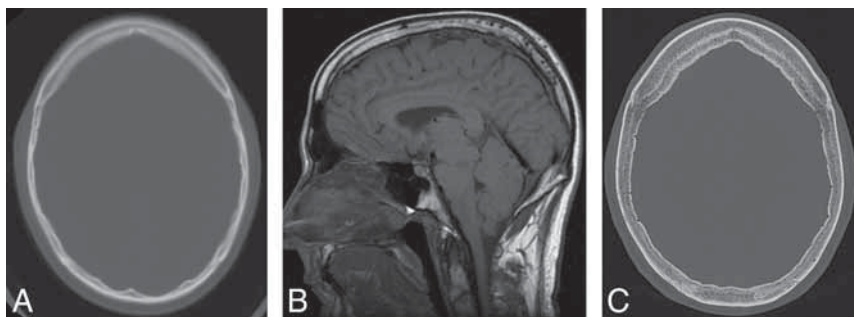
Development of hyperostosis in a 67-year-old man with 2 decades of waxing and waning SIH symptoms with a history of remote CSF leak at C2–C4. A, Axial CT head image at 45 years of age shows qualitatively normal calvarial thickness. B, Sagittal T1-weighted MR image at 48 years of age demonstrates severe brain sag and a suggestion of developing layered hyperostosis. Diffuse pachymeningeal thickening and enhancement are also present (not shown). C, The most recent axial head CT at 67 years of age demonstrates new layered calvarial hyperostosis.
